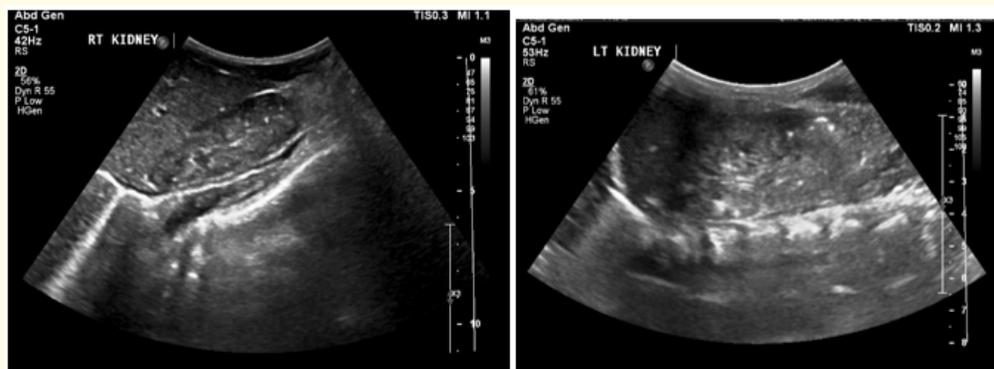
Renal ultrasonographic at age of 1 year.
